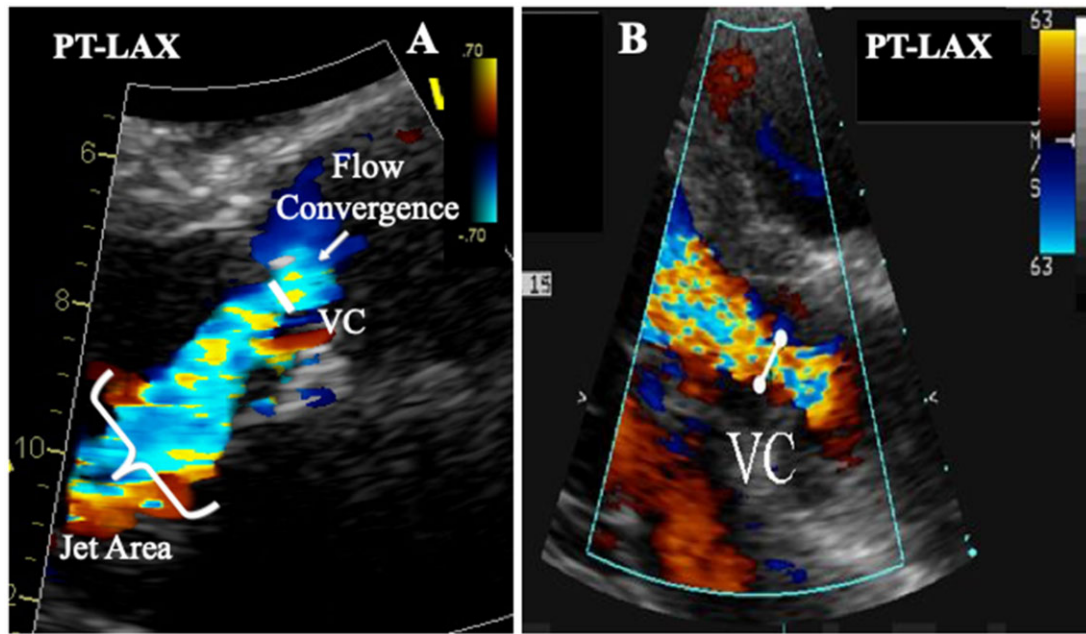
(A) Semi-quantitative assessment of AR severity using the vena contracta width (VC). The three components of the regurgitant jet (flow convergence zone, vena contracta, and jet turbulence) are obtained. (B) Assessment of the VC in a patient with a AR jet directed towards the septum. PT-LAX, parasternal long-axis view.
